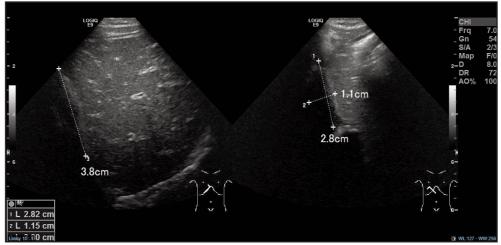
Septated right subdiaphragmatic hypoechoic collection on ultrasound of the abdomen.
